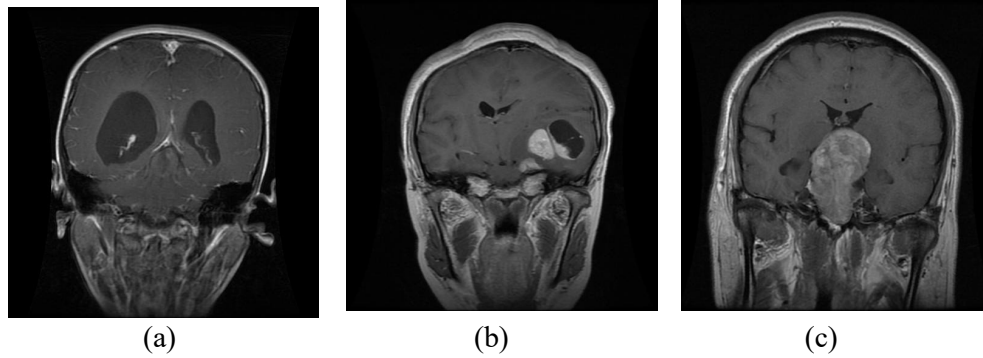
(a) MRI image of a patient with glioma tumor. (b) MRI image of a patient with meningioma tumor. (c) MRI image of a patient with a pituitary tumor.
